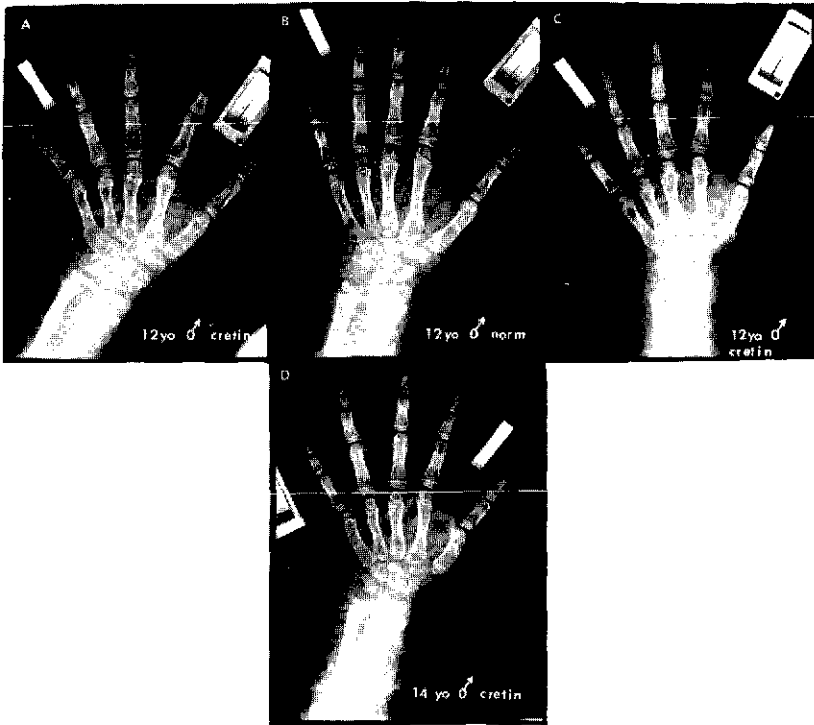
Hand x-rays of four Ecuadorian children of similar chronologic age; three (A, C, D) are cretinous while "B" is a goitrous but non-cretinous individual from the same area. Note that cretin "A" is not delayed maturationally or linearly when compared to the non-cretin while cretin "C" falls behind in both of these parameters. Hand film "D" is of a severely skeletally retarded cretinous individual. The metacarpal-phalangeal disproportion present among some adult cretins is not seen in any of the child examples.
